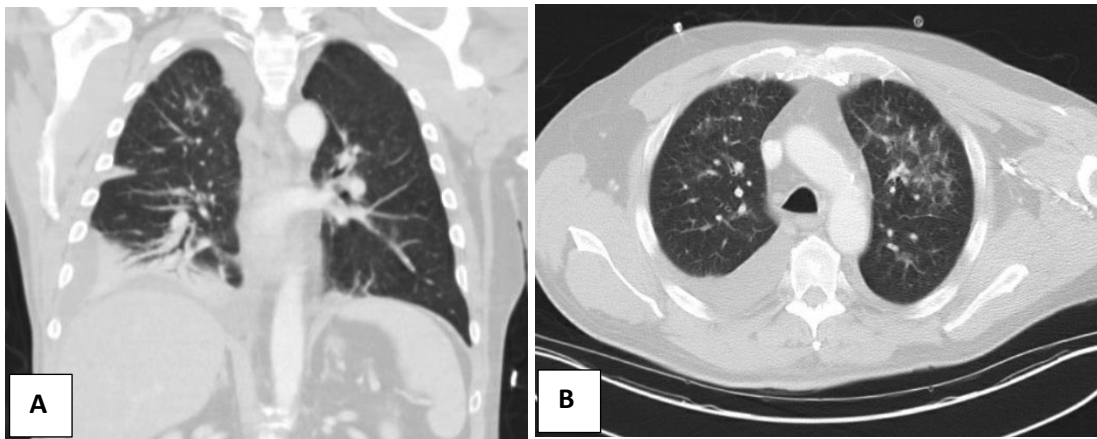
CT thorax showing bilateral confluent, diffuse, ground-glass opacities of the lungs.
